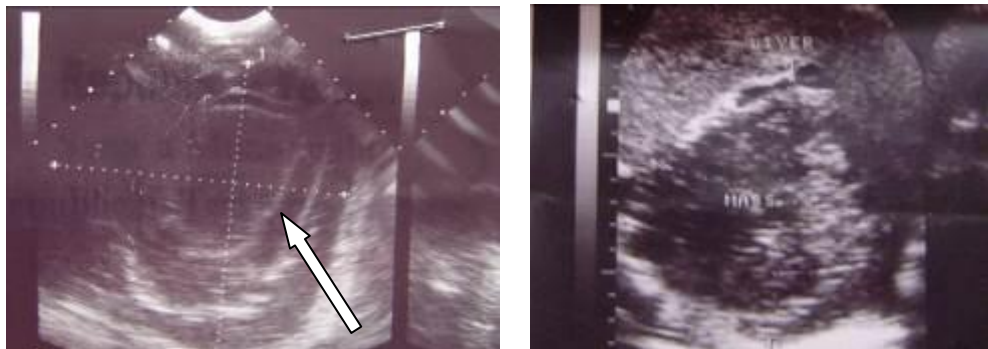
ultrasound finding: Ascaris in common bile ducts.
